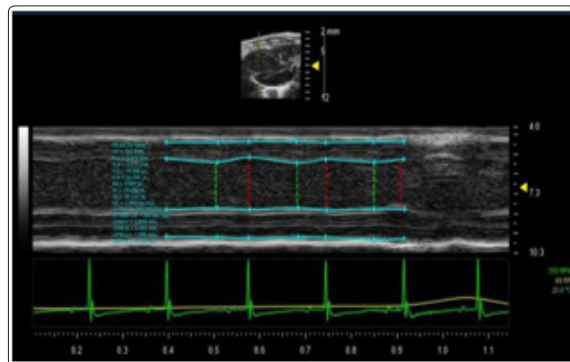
M ultrasound in the model group on the 15 day, the amplitude of left ventricular posterior wall motion was decreased significantly.
